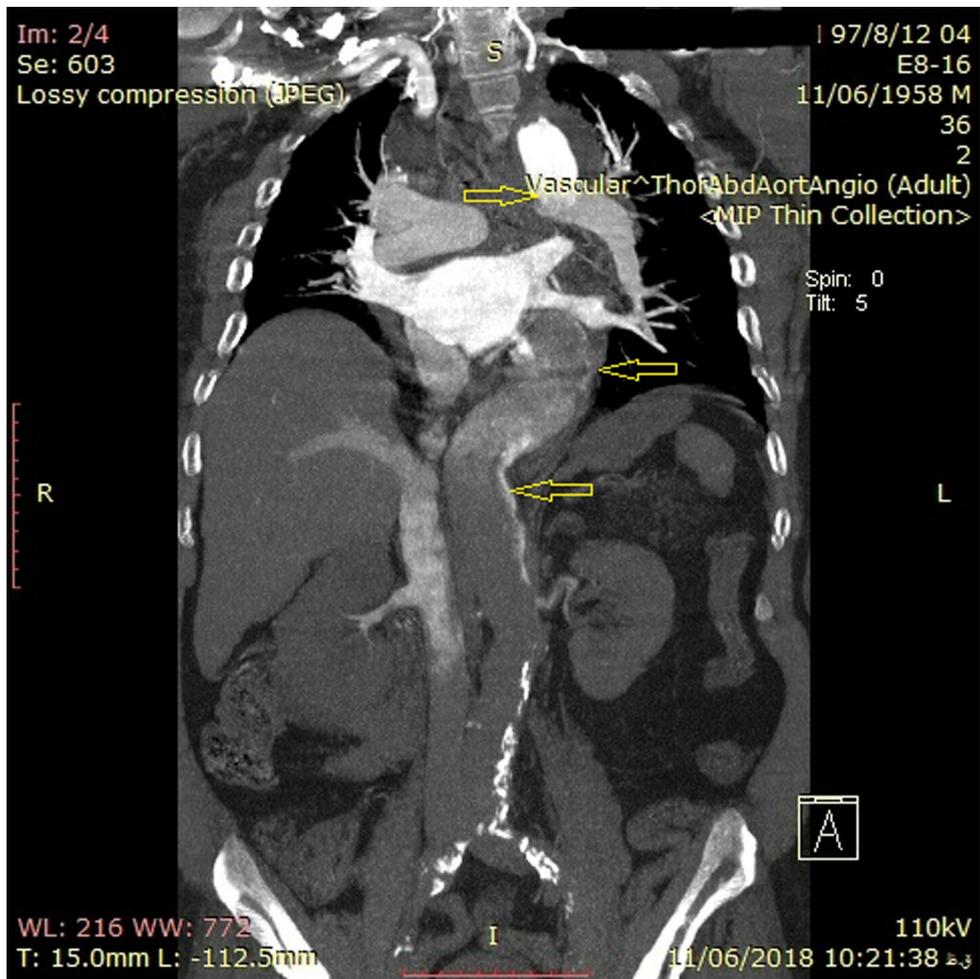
Coronal view of dissected thoracic and abdominal aorta in CT-angiography.
